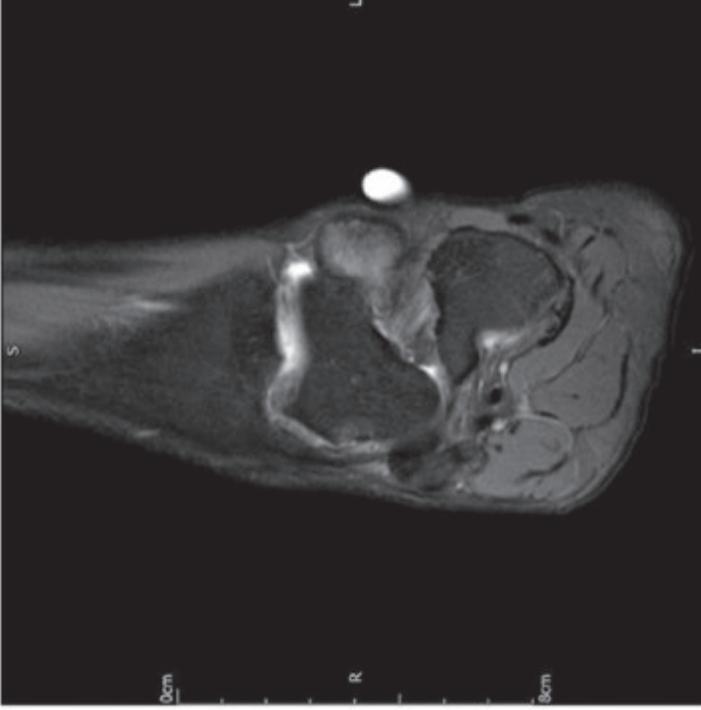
Coronal T2 MRI images showing a well-circumscribed lesion in the subarticular joint, presenting localised-type TGCT. The white spot indicates the location where the patient experiences most complaints
